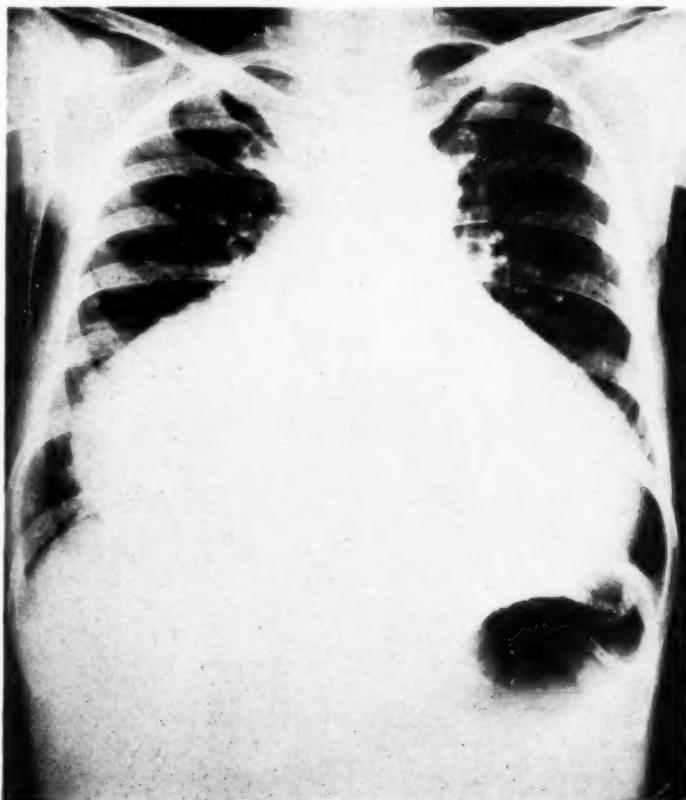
(M. S.) Roentgenogram of the thorax revealing marked cardiac enlargement.
